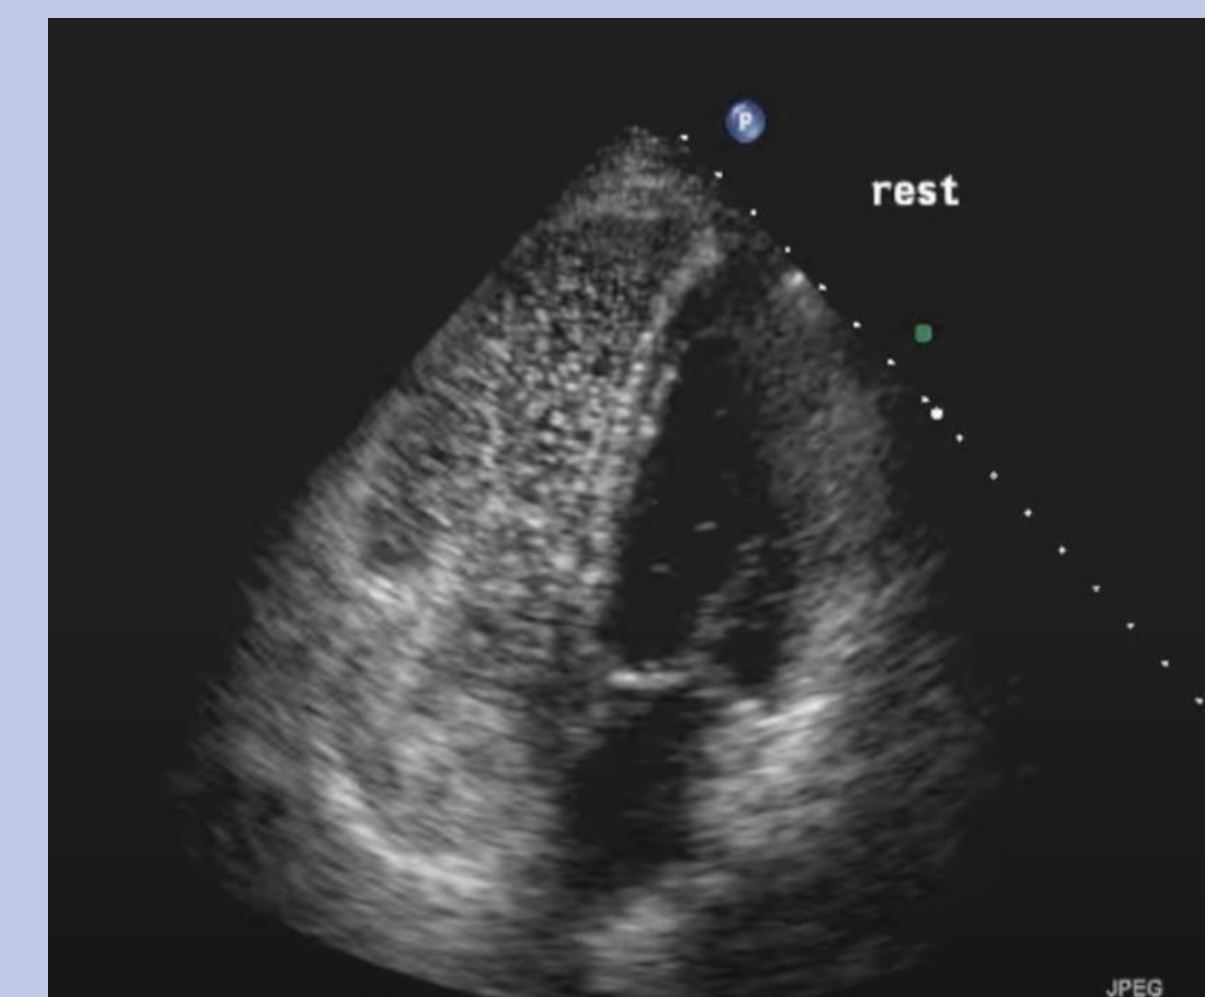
2D echocardiogram reveals the presence of air in the right ventricle and atrium during a bubble study.
